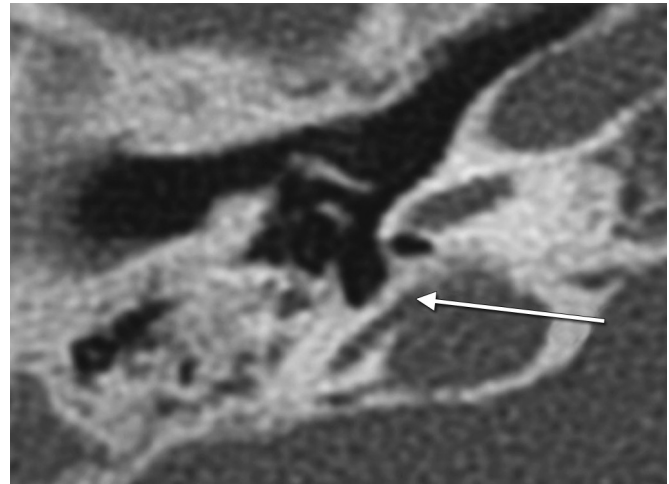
Computed tomography (CT) scan (axial section) of a right ear. The posterior semicircular canal is dehiscence into the jugular fossa (arrow).
